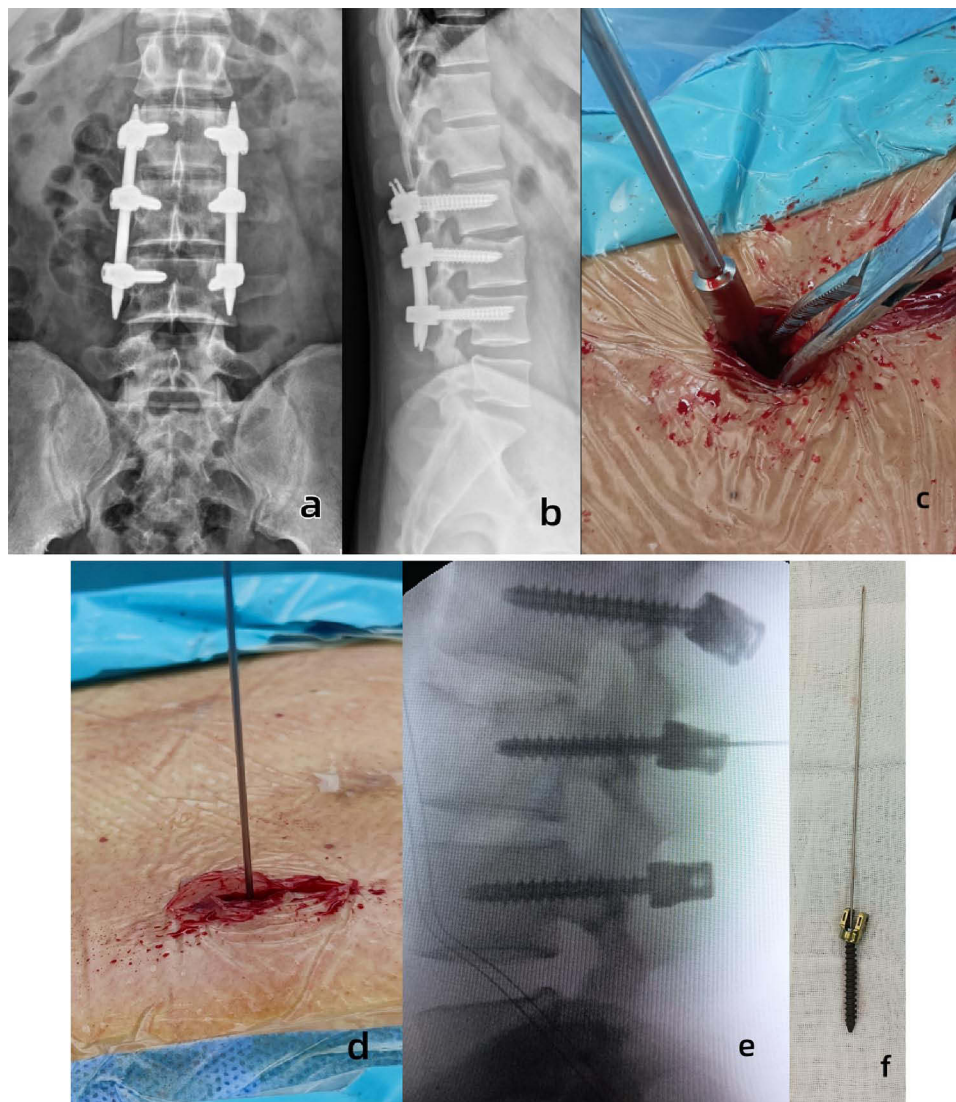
Typical case. Male patient aged 25 years with a history of L3 fracture caused by a car accident 1 year before. (a) Anteroposterior X-ray film before hardware removal. (b) Lateral X-ray film before hardware removal showing bone healing. (c) Incision distraction by the vessel clamp and system-specific set screw retaining compressor insertion. (d) Kirschner wire insertion in a blind manner with the blunt end ahead. (e) Lateral X-ray after Kirschner wire insertion into the axial channel of a percutaneous pedicle screw. (f) Status of the screw with Kirschner wire after removal. A sharp end can be observed on the opposite side of the screw head, indicating that the blunt end was in the screw.
